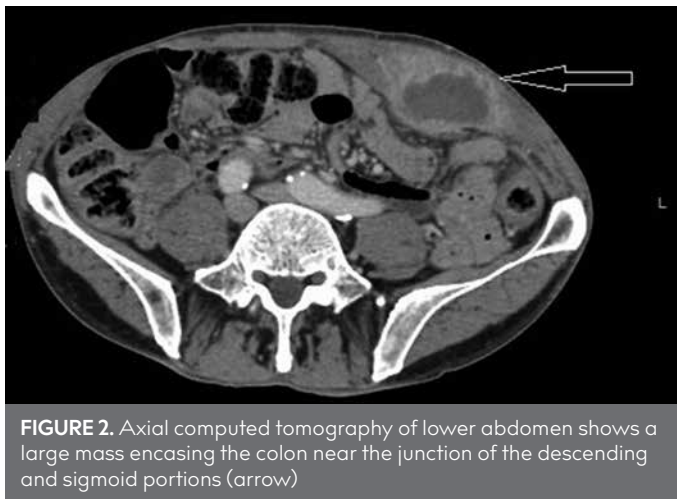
Axial computed tomography of lower abdomen shows a large mass encasing the colon near the junction of the descending and sigmoid portions (arrow)
